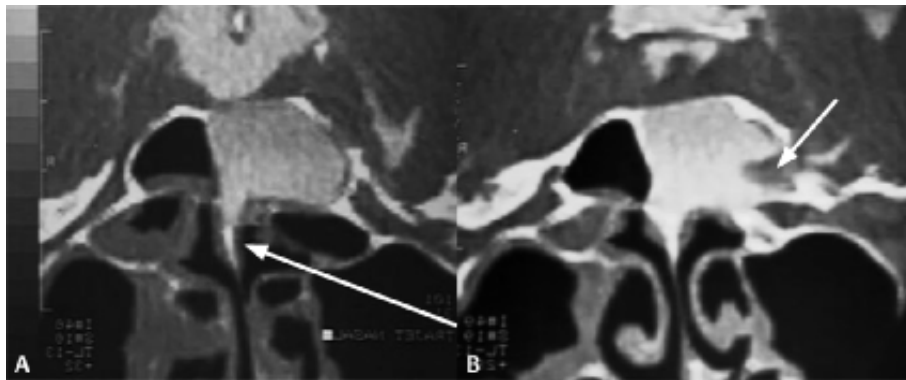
Coronal CT cisternogram. A and B Meningeal protrusion occupying the left sphenoid sinus (red arrow).
